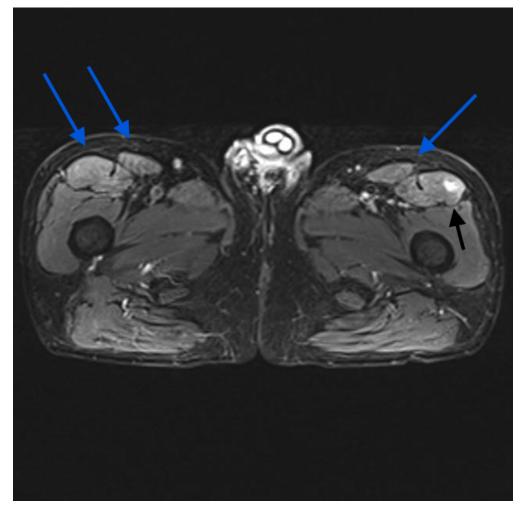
MRI scan. Blue arrows: foci of oedema-like signal within the thigh muscles, most prominent in the rectus femoris, semi membranous and semi tendinous muscles bilaterally, in keeping with myositis. Black arrow: 10x8 mm fluid signal focus within the proximal left rectus femoris, representing a small intramuscular collection.
